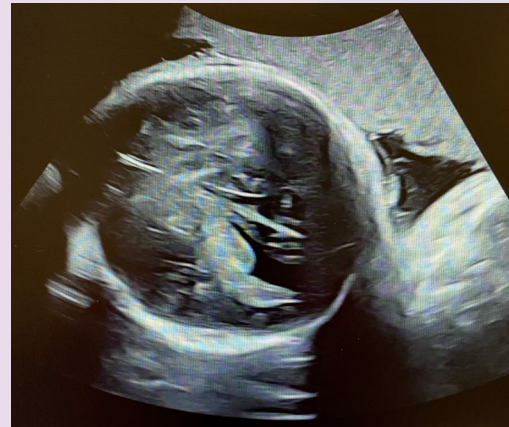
Ultrasound: foetal head
